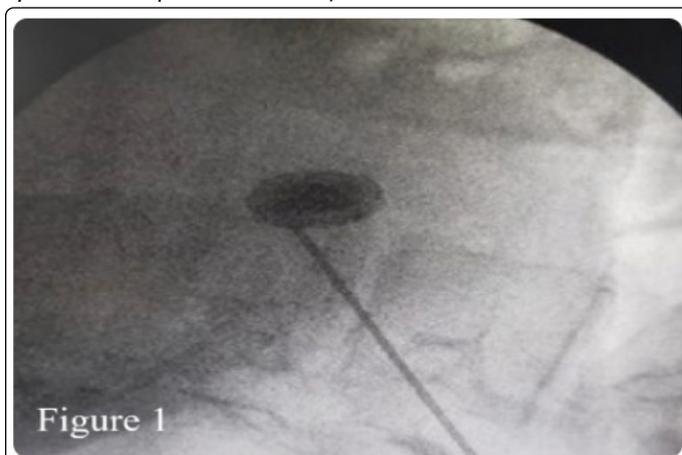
Ultrasound-guided entry into the calyceal system.
